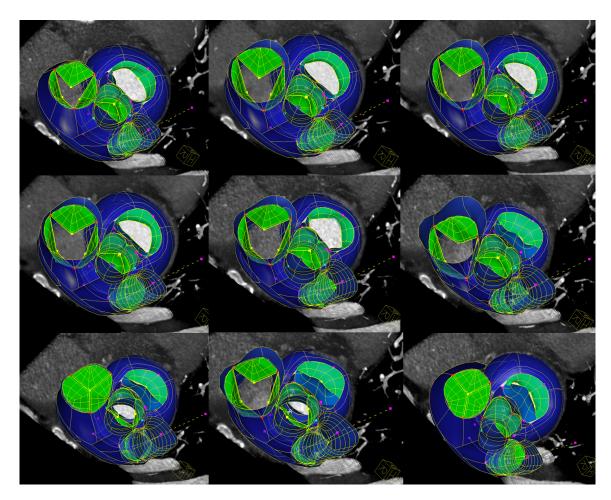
Examples of the complete valves model estimation in cardiac CT of all heart valves during one cardiac sequence.
